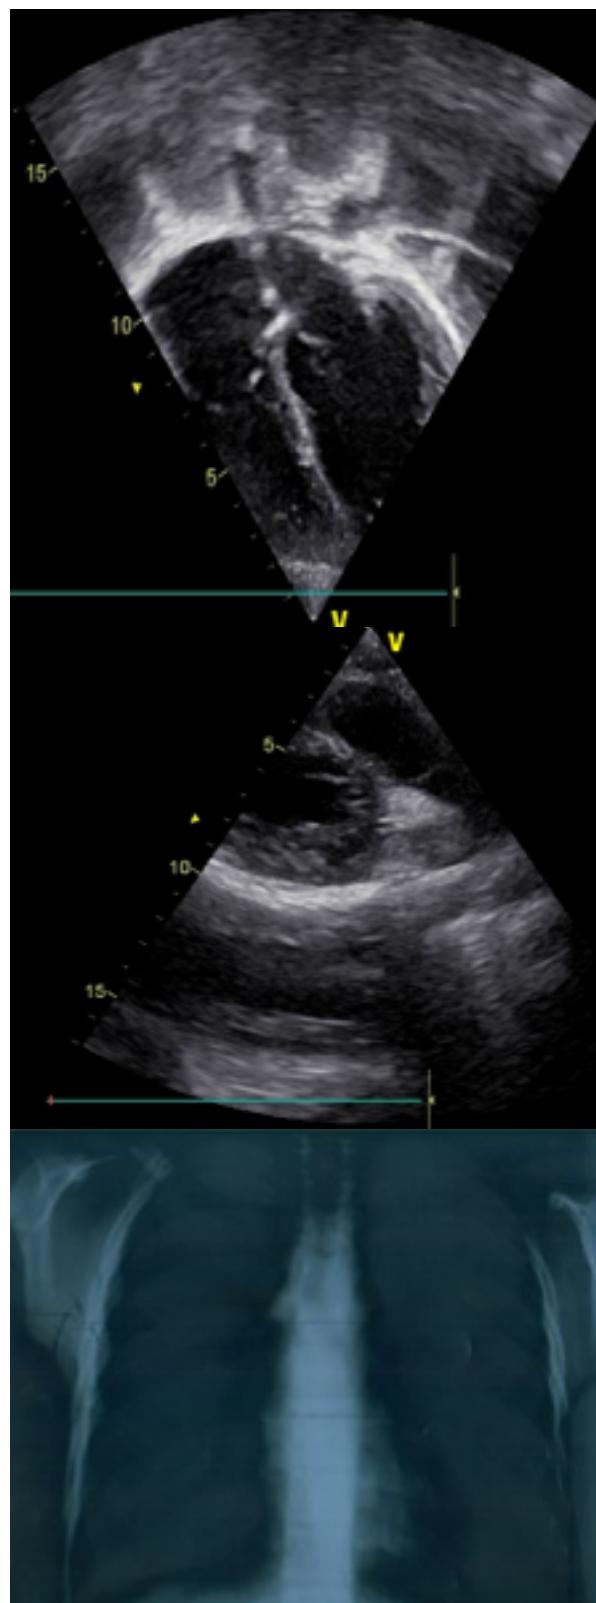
Echo & X-Ray after six weeks of anti-TB treatment
